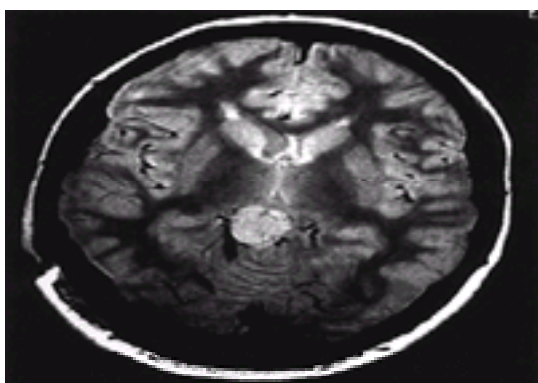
Axial, primarily T₂-weighted MRI of a pineocytoma: this tumor is located posterior to the third ventricle, anterior to the cerebellar vermis, and just to the right of the midline; note the significant vascular flow voids adjacent to the lesion and the relatively clear delineation between tumor and normal parenchyma.
